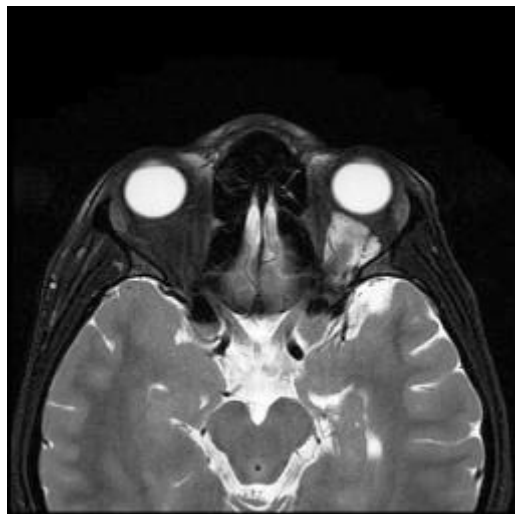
Axial T2-weighted MR image in prone position, revealing left sided intraconal mass lesion
